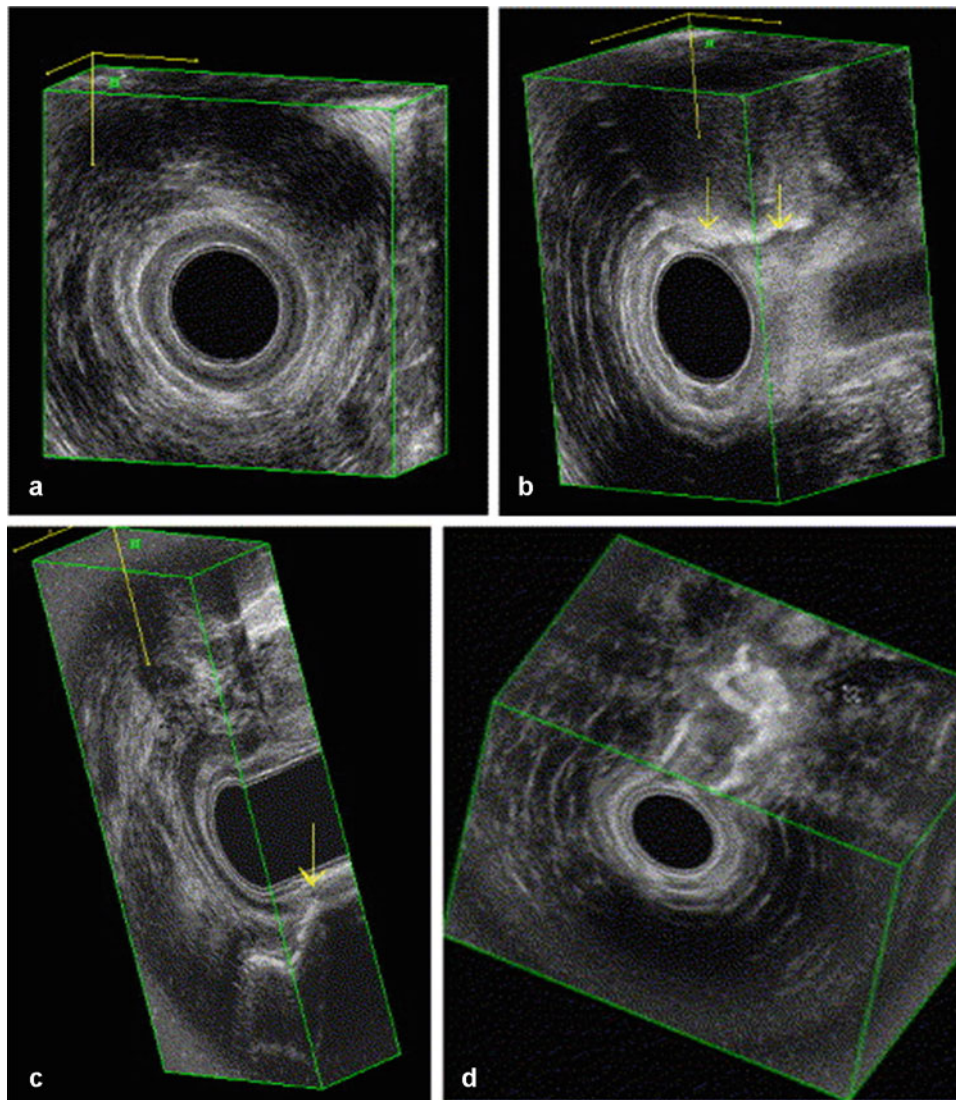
Anal endosonography. Normal anatomy of the anal sphincter and puborectal muscle in 3D imaging: (a) frontal view of puborectal muscle (PR); (b) frontal view of the anal sphincters; (c) lateral view; and (d) coronal view. *SM* submucosa, *IAS* internal anal sphincter, *EAS*
